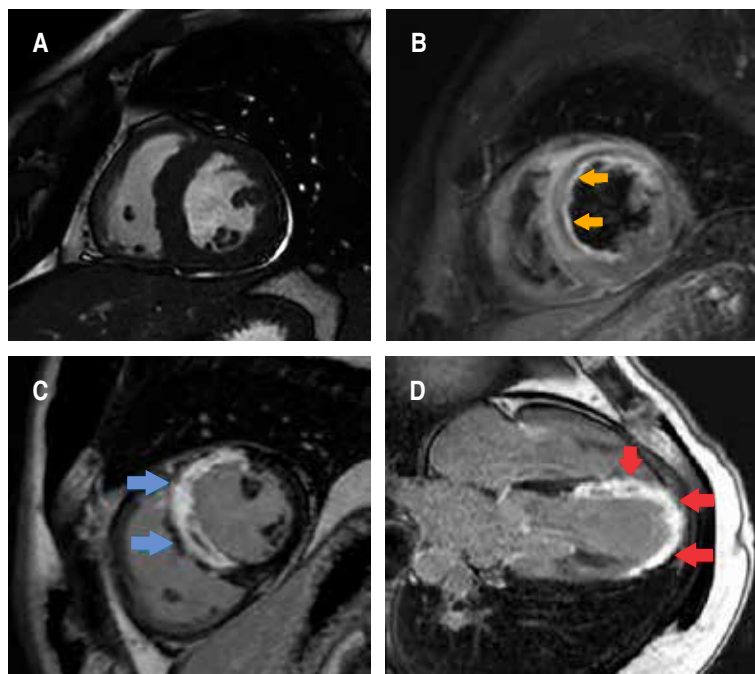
Cardiac magnetic resonance imaging: A) Short-axis cine at the mid-ventricular level (SSFP [Steady-State Free Precession]). B) Short-axis T2 STIR (Short Tau Inversion Recovery) showing transmurular myocardial hyperintensity compatible with edema (yellow arrows). C) Short-axis late gadolinium enhancement (T1 GRE I-R [Inversion-Recovery Gradient Echo]) showing transmurular enhancement in the anterior and anteroseptal walls (blue arrows). D) Four-chamber long-axis late gadolinium enhancement (T1 GRE I-R [Inversion-Recovery Gradient Echo]) involving the septal and lateral segments at the basal, mid, and apical levels (red arrows).
